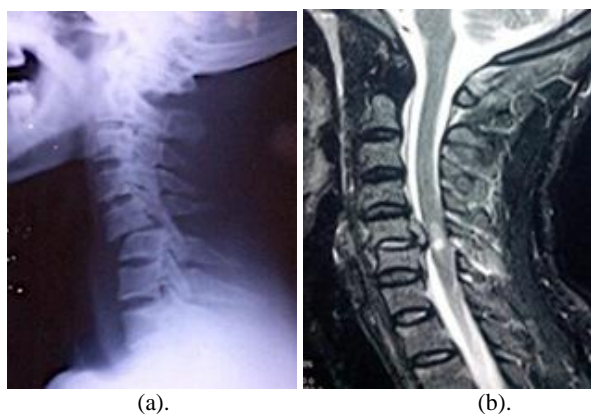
Preoperative X-ray showing C5/C6 dislocation (a) and preoperative MRI (b).
